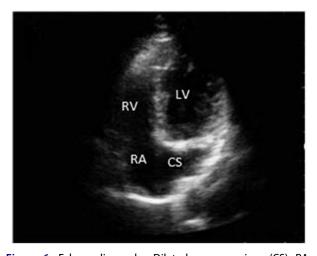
Echocardiography. Dilated coronary sinus (CS). RA: right atrium; RV: right ventricle; LV: left ventricle.
